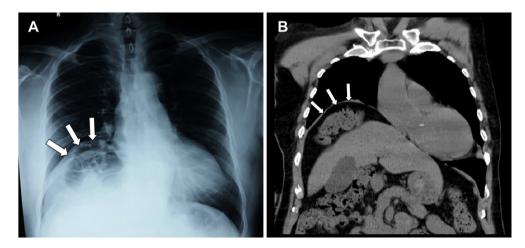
(A) shows an elevated right hemi-diaphragm with underlying gas filled bowel loops while CT scan (B) showed the hepatic flexure of the colon filled with faeces, interposed between the elevated right hemi-diaphragm and the liver.
